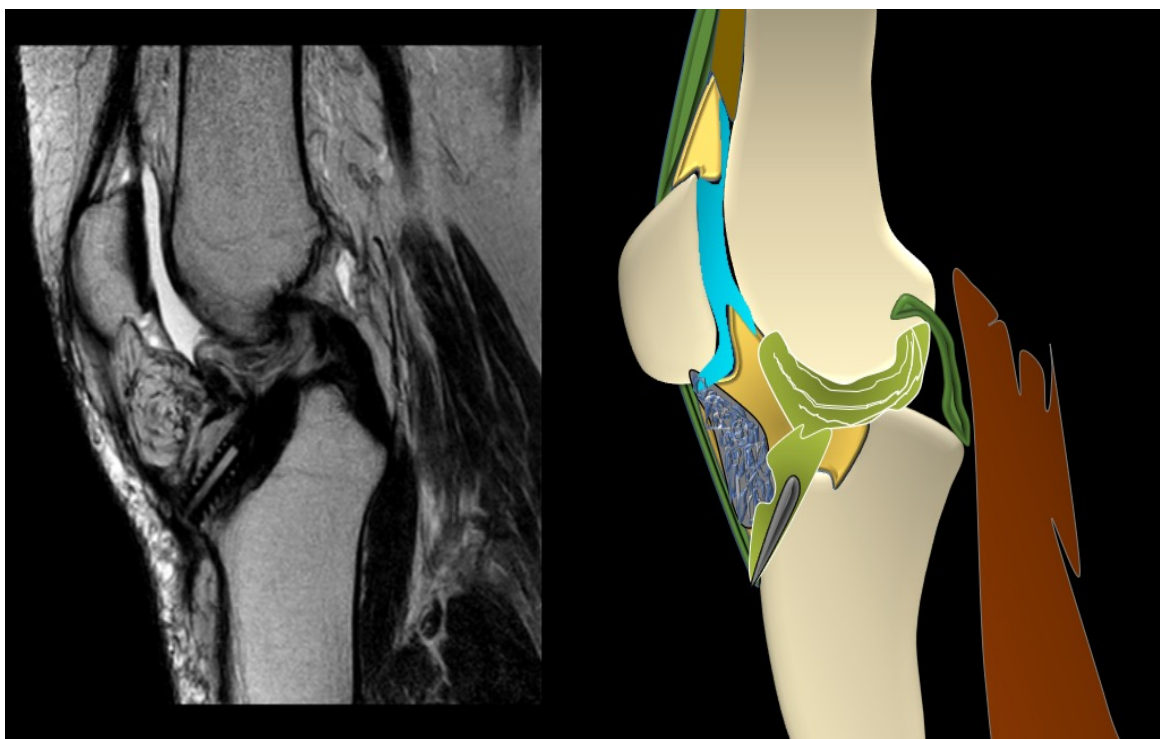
T2W sagittal MRI shows localized/focal arthrofibrosis and hoffas fat pad fibrosis.
